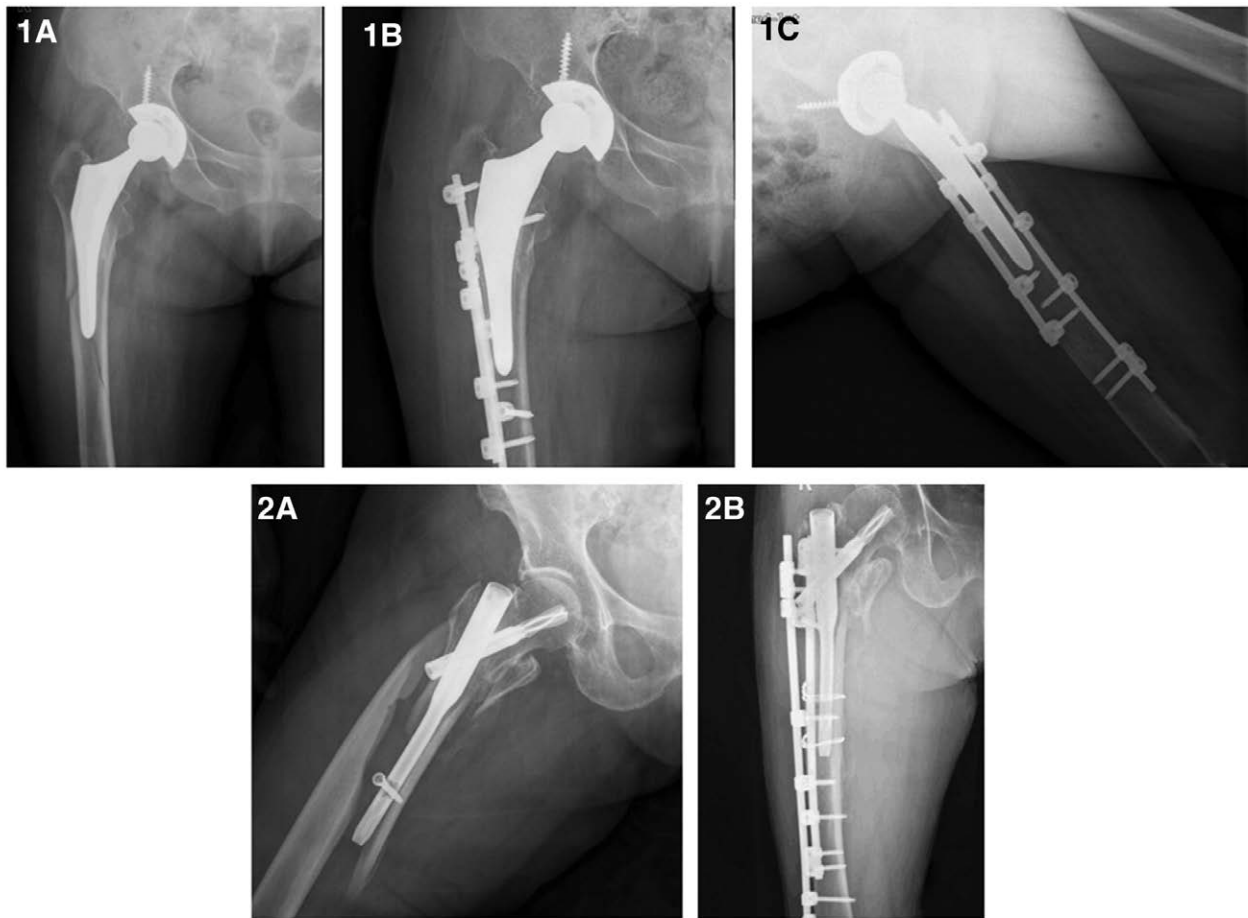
A 78-year-old female patient suffered periprosthetic femoral fractures one year after total hip replacement surgery for a femoral neck fracture due to a fall; (1a) X-ray before operation and (1b and 1c) three months after operation showing that the fracture has been reduced properly and the fracture has healed. An 82-year-old female patient suffered intramedullary nail fractures due to a falling injury after closed reduction and PFNA internal fixation of intertrochanteric fracture of femur; (2a) X-ray before operation and (2b) six months after operation, showing that the fracture has been reduced properly and the fracture has healed. BCFSSs (Weiman, China) were used in both cases.
